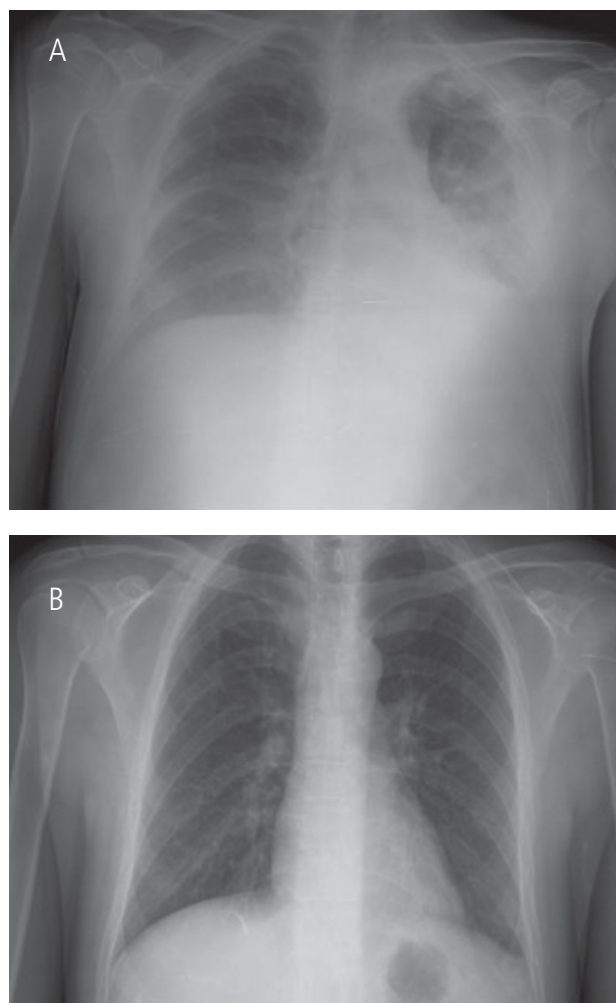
A, Chest x-ray showing bilateral pleural effusion during an acute episode of DRESS syndrome. B, After resolution.
